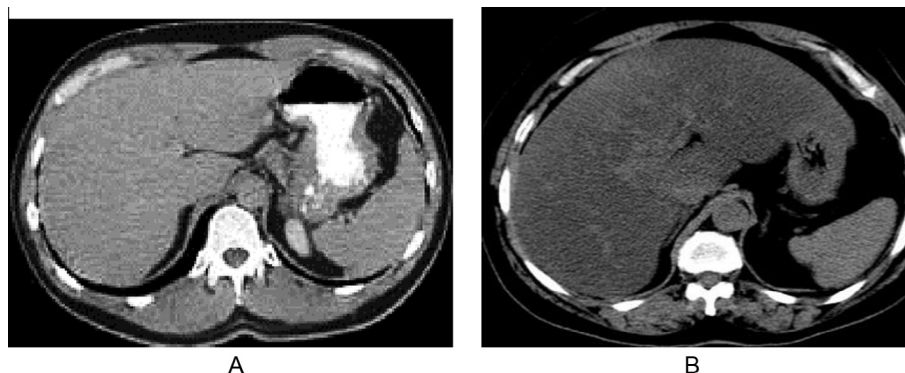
44-Years-old female patient underwent mastectomy for cancer breast and received 6 cycles of FAC. Abdominal CT scan was done. (A) Post oral and before IV contrast abdominal CT scan before starting chemotherapy regimen which is normal. (B) Non-contrast abdominal CT scan, 6 months after starting chemotherapy regimen which revealed diffuse hepatic fatty infiltration (hypodense liver parenchyma).
